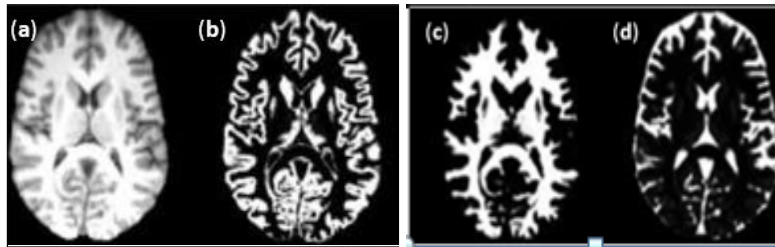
MRI images of normal brain (a) original, (b) GM, (c) WM and (d) CSF
